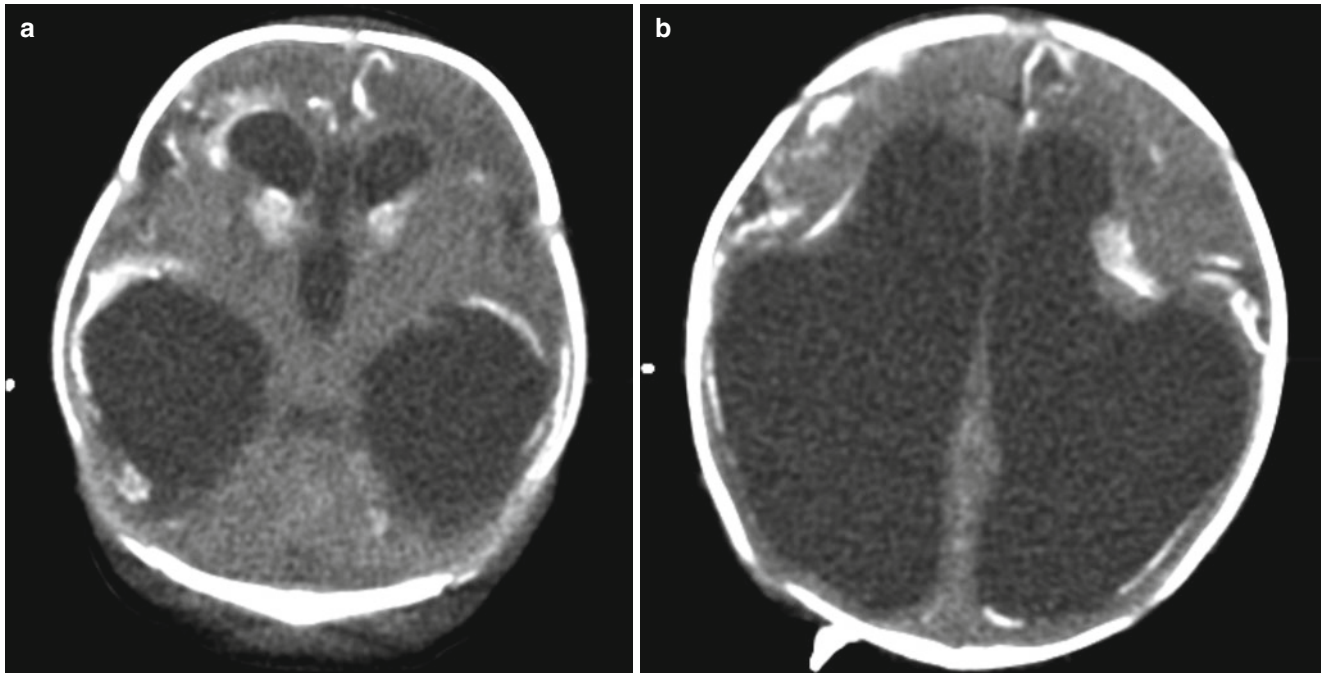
A neonate with congenital toxoplasmosis. (a) CT shows markedly dilated lateral and third ventricles with ventricular wall calcifications. (b) Severe cortical thinning with multiple parenchymal and deep nuclear calcifications along with the ventricular wall calcifications
